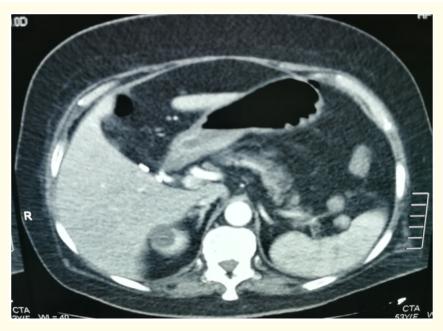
CT scan of the abdomen showing free intra-abdominal air.
